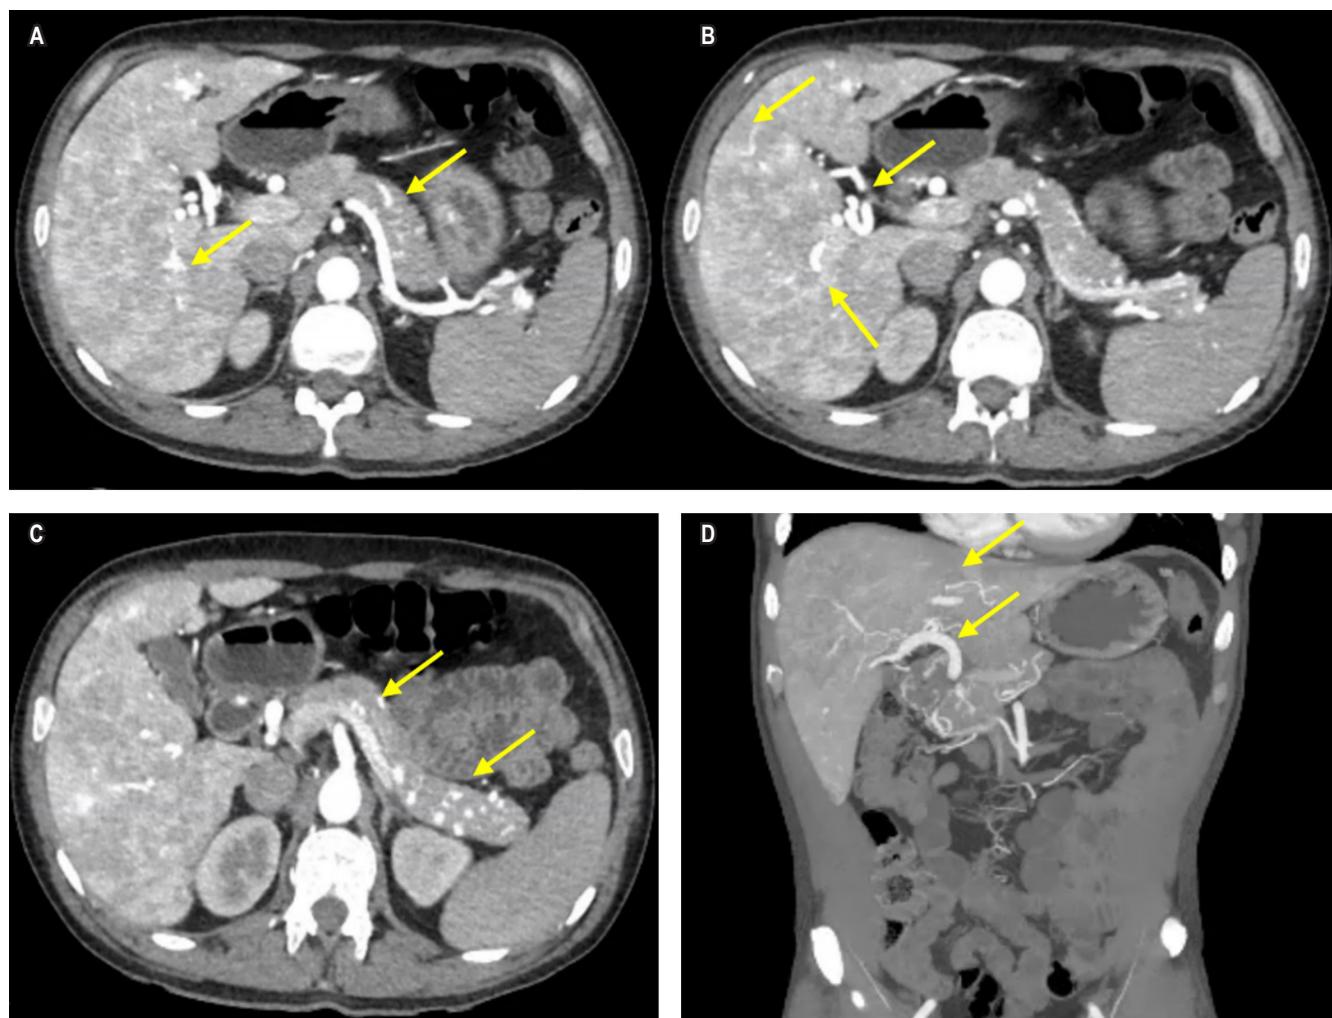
Abdominal angio-CT demonstrating multiple hepatic and pancreatic AVMs (arrows). Images property of the authors.
